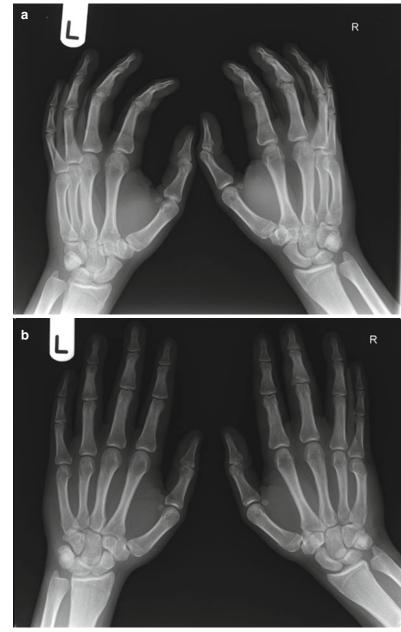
A 23 year old man presented with pain and swelling in his right middle finger PIPJ after a fall onto both hands. Oblique (a) and posterior-anterior (b) radiographs of the hand were obtained. Can you diagnose the problem?
